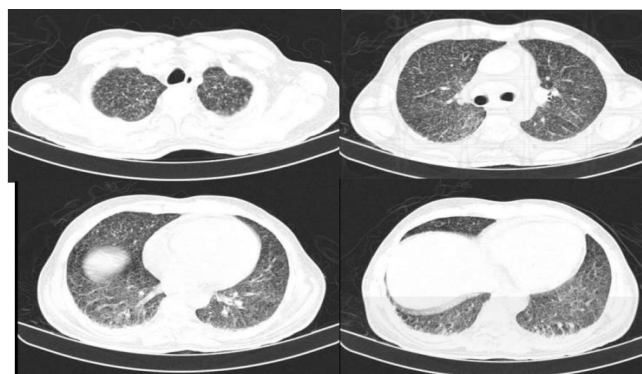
CT Thorax showing military deposits
